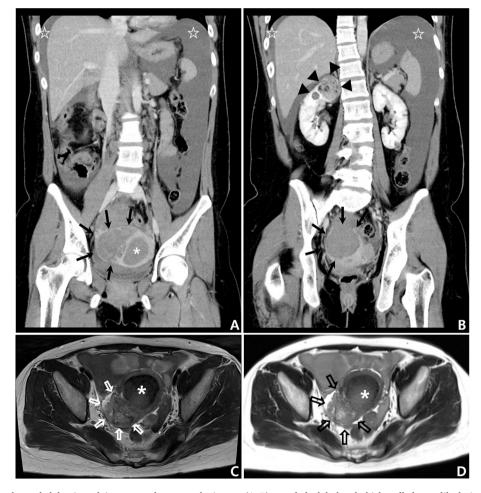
Coronal contrast-enhanced abdominopelvic computed tomography images (A, B) revealed a lobulated, thick-walled mass like lesion (arrows) communicating with a dilated endometrial cavity filled with hematometra (asterisk) and massive hemoperitoneum up to diaphragm (open asterisk). Multiple angiomyolipomas up to 4 cm are present in the right kidney (triangle). Axial T1-weighted image (C) and axial T2-weighted image (D) show mixed low and high signal intensity of a lobulated mass suggestive of hematoma (open arrows) in right pelvic cavity, with a focal uterine wall rupture on the right side of the uterus. The uterine cavity (asterisk) is dilated and filled with hematoma.
